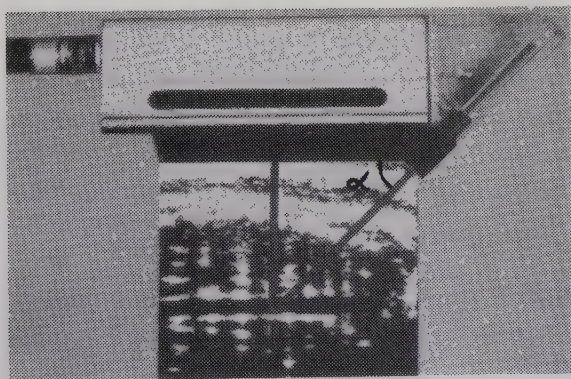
The real-time ultrasound transducer with the pulsed Doppler transducer attached at a fixed angle of 45° . The course of the Doppler beam is marked in the real-time image of a longitudinal section of the fetal body with the descending aorta.
